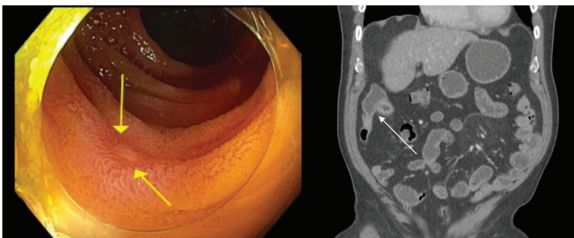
Representative endoscopic and computerized tomography (CT) images demonstrating shallow ulceration in the distal ileum and corresponding mural thickening and bowel wall enhancement in a 56 year old male with obstructive symptoms.
